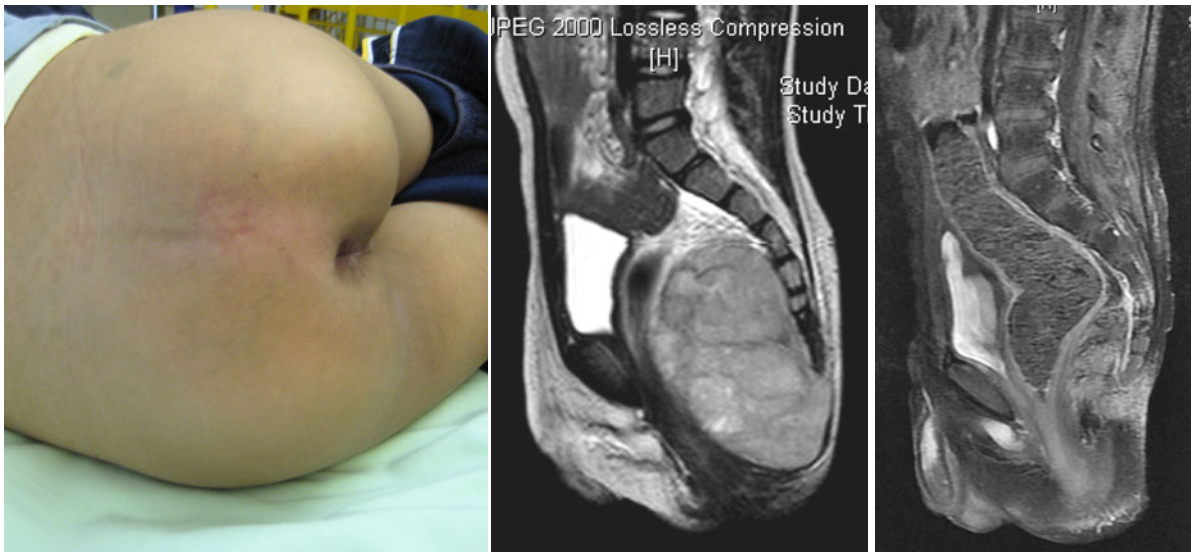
Sacrococcygeal yolk sac tumor (Altman III/IV) in a 3-year-old boy: clinical presentation and MRI prior to (*left*) and after (*right*) chemotherapy with three cycles of cisplatin, etoposide, and etoposide
